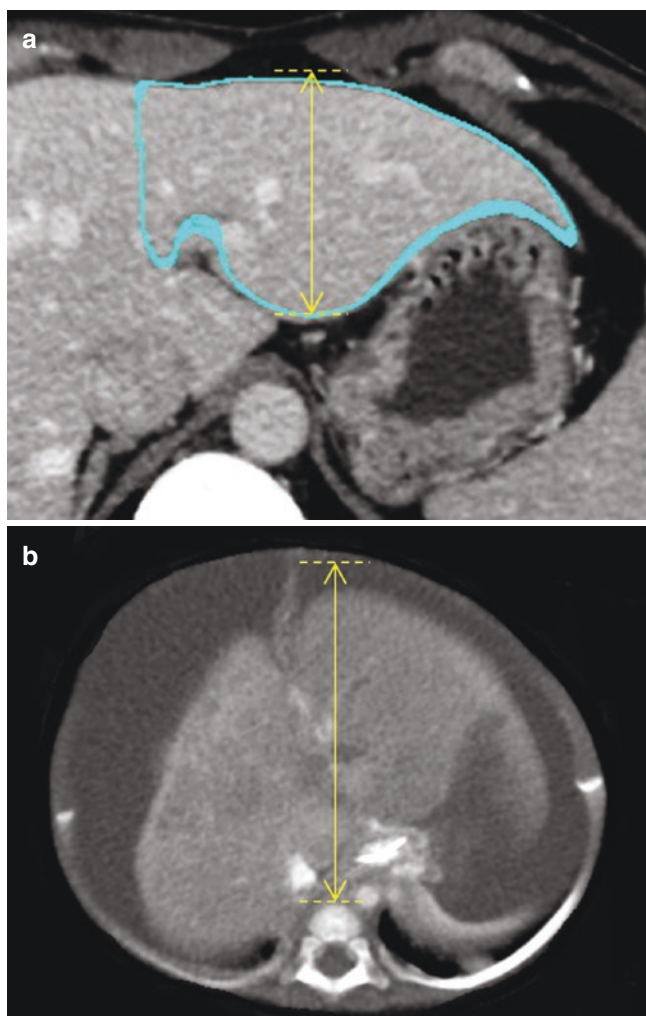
(a) The maximum thickness of the donor left lateral segment graft. (b) The anteroposterior (A-P) diameter in the recipient abdominal cavity. From the perspective of the graft shape, if the LLS of the donor was bulky, and its maximum thickness was larger than the anteroposterior (AP) diameter in the recipient's abdominal cavity, which was identified as the length from the inside abdominal wall to the front of the vertebra on axial computed tomography images, a segment II graft was considered (when the ratio of thickness [= graft thickness/recipient A] more than 1.0)
